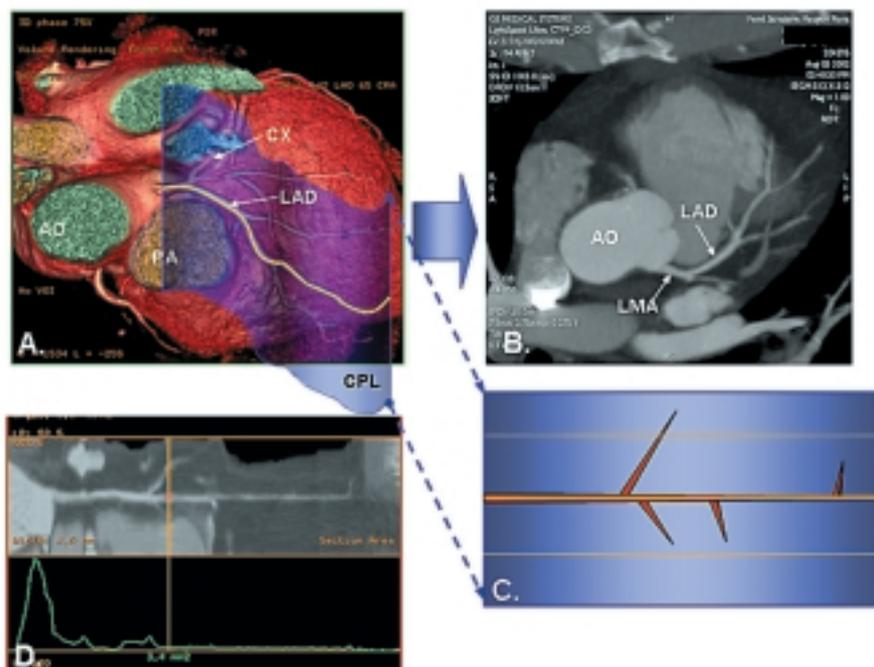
Modality of multislice spiral computed tomographic image reconstruction. A: the curved plane that intercepts the coronary vessel, identified semi-automatically by algorithms of recognition based on the contrast density, is represented on a single plane (B). Other algorithms of reconstruction enable a rectilinear visualization of the principal coronary axis (C and D), for a better analysis of the vessel lumen. AO = aortic root; CPL = curved plane; CX = circumflex coronary artery; LAD = left anterior descending artery; LMA = left main artery; PA = pulmonary artery.
